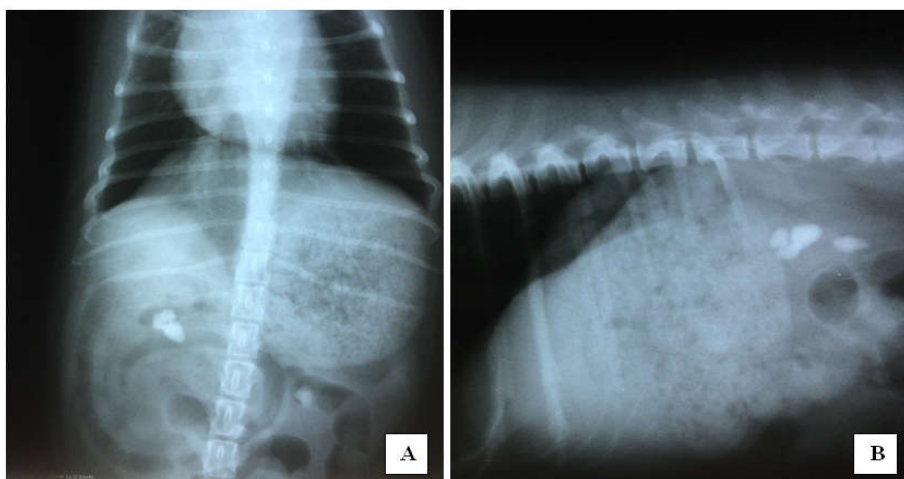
(A). Radiography exam of the spine (thoracolumbar region), showing the presence of radiopaque area on the bilateral kidney region. Figure 1 (B). Exame of the spine, thoracolumbar region, in the ventro-dorsal projection (VD), suggesting the presence of calculus, because of the radiopaque area in the bilateral kidney region
